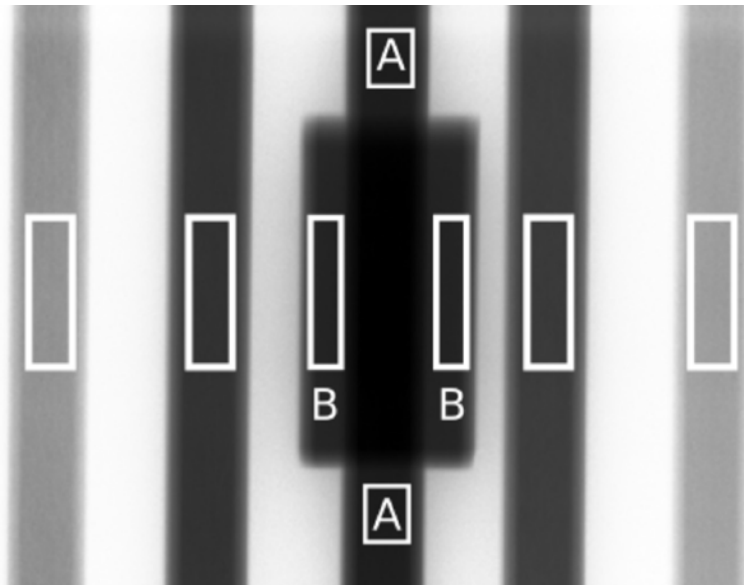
Radiograph used for alternative method B for checking grid alignment. The caudal-cranial axis is top to bottom. Regions A are at detent at full air kerma; Regions B are at detent but at 20% reduced air kerma. Measurements in Regions A are averaged to minimize the heel effect; measurements in Regions B are averaged to account for variations in the grid transmission.
